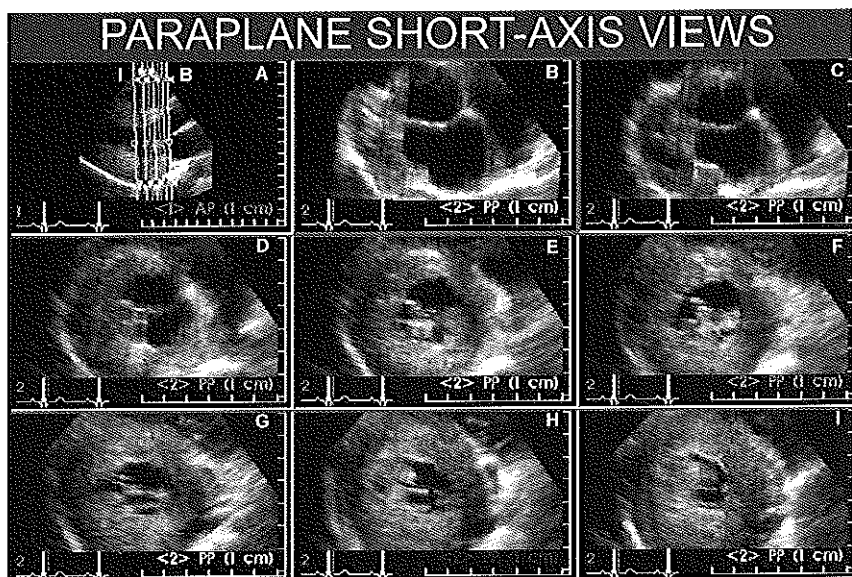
Paraplane echocardiography using the three-dimensional data set of a patient with hypertrophic cardiomyopathy. The parasternal long-axis view is shown in panel A and the lines indicate the computer generated parallel short axis views of the left ventricle from B to I.
